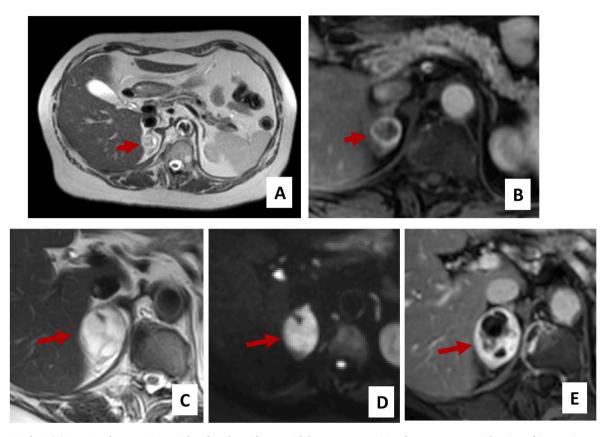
MRI Axial T2 (A) imaging shows a 1.9 cm right adrenal ovoid mass with heterogenous T2 signal. Post-contrast axial region of interest images shows rim enhancement (B). Follow-up MRI Axial T2 (C) imaging obtained 9 months later show significant increase in size of the right adrenal mass compared to prior study, now measuring 4.3 cm consisting of predominantly T2 hyperintense signal with hypointense septations. Diffusion weighted imaging (D) shows diffusion restriction. Dynamic post-contrast T1 image obtained at 6 minutes (C) shows progressive enhancement of the mass with non-enhancing internal component. In and out of phase images (not pictured) showed no significant signal drop-out comparing out of phase to in phase, confirming a lack of intralesional fat.
